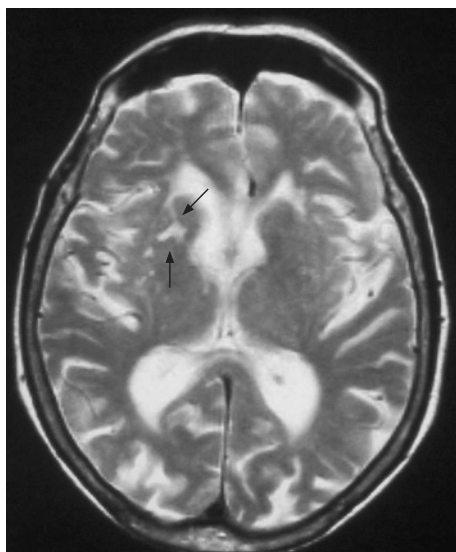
Magnetic resonance image executed 6 months after the onset, showing a right capsuloputamenal infarct.
